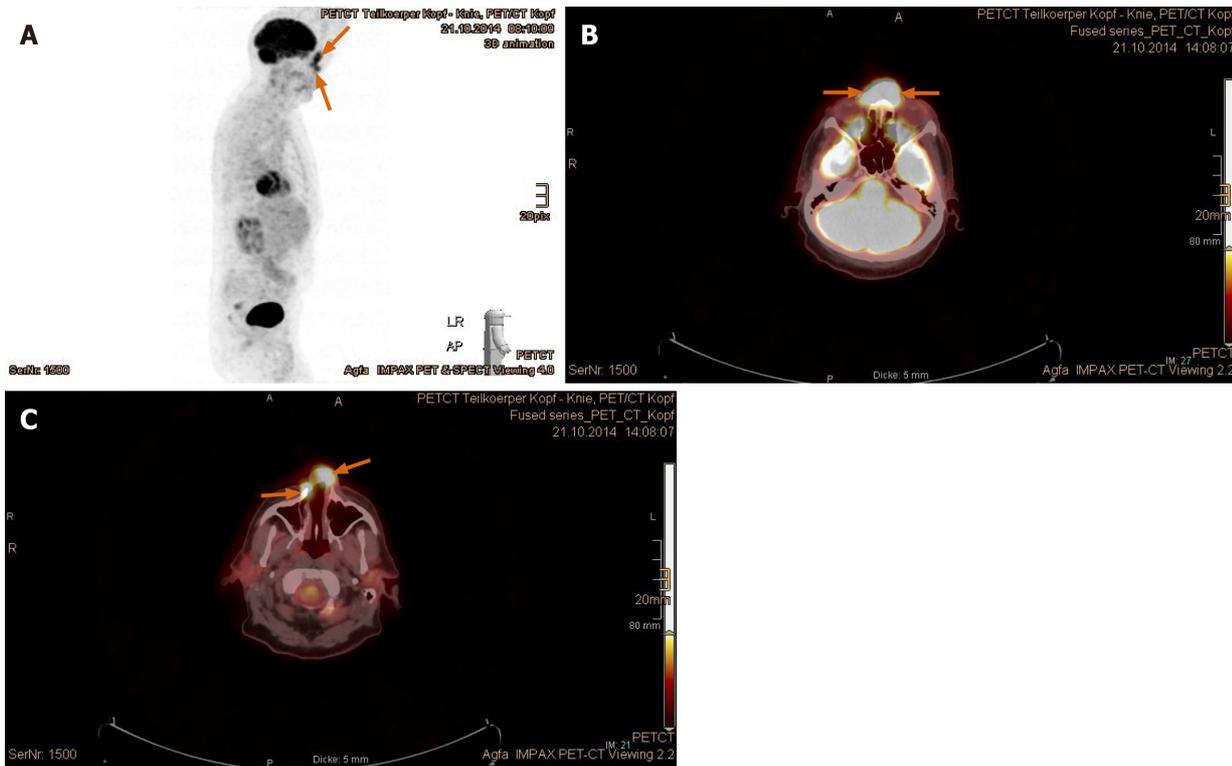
Positron emission tomography with 2-deoxy-2-fluorine-18-fluoro-D-glucose/computed tomography validated tumor recurrence in the nasal bridge and left parotid gland. A: Positron emission tomography overview image; B: Increased uptake in the nasal bridge; C: Fluoro-D-glucose-avid tumor in the nostrils (recurrent tumor marked with arrows).
